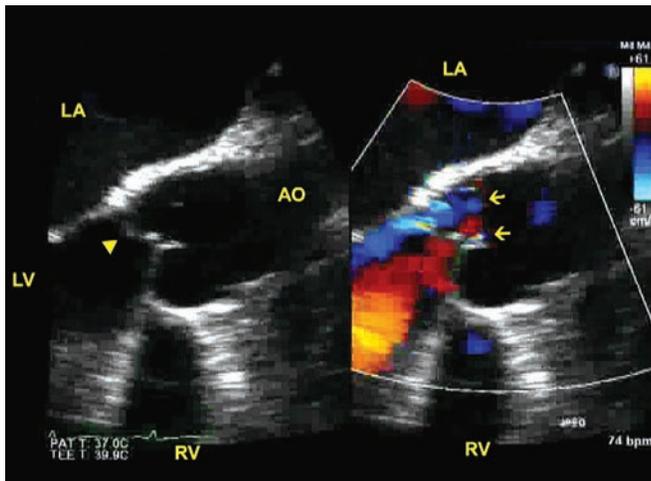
Transesophageal echocardiography. Arrows point to 2 jets of aortic regurgitation. Arrowhead points to a prolapsed leaflet.
